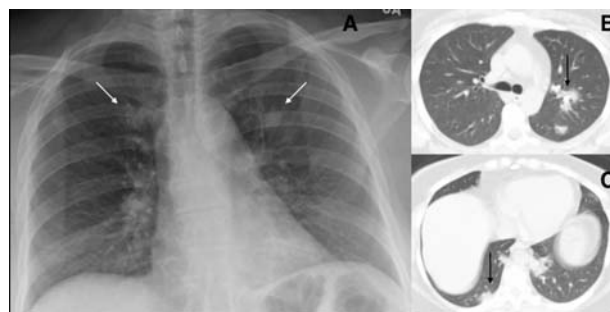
Atypical presentation of COVID-19 in the form of nodules (arrows) seen on the CXR (A) and the corresponding CT (B). Image reproduced with permission from Covid-19 Database of the Fleischner Society.
